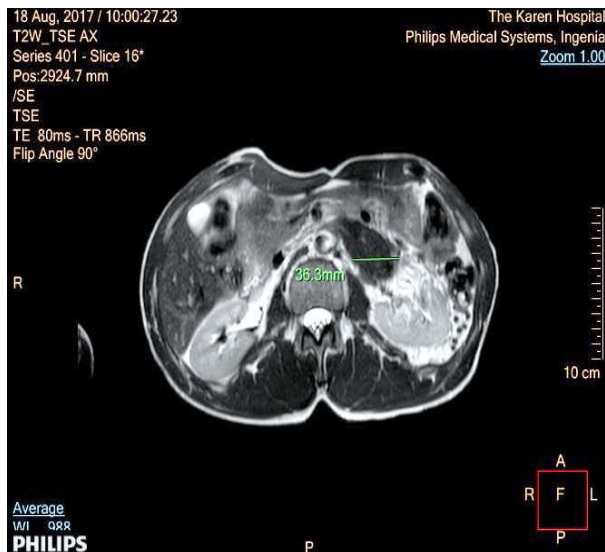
MRI T2W\_TSE axial View
